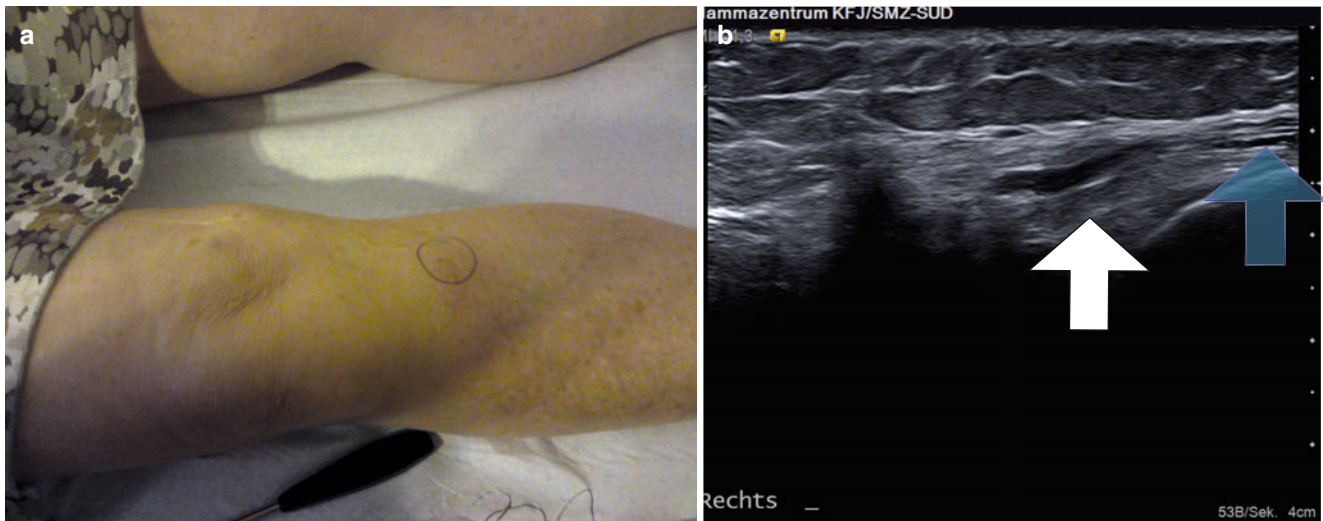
Neuroma of the infrapatellar nerve: (a) After venous stripping, the patient experienced neuropathic pain in the distribution of the infrapatellar nerve. (b) Ultrasound showed a small neuroma (white arrow; the blue arrow shows the saphenous nerve)
